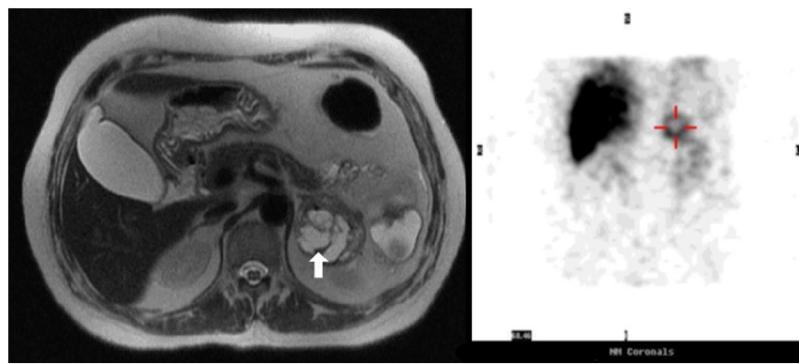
On the left: MRI, on T2, shows a 5.2 cm partially cystic mass (arrow) with a hyperintense solid component on T2. On the right: 123I-metaiodobenzylguanidine (MIBG) scan reveals high uptake of the lesion, that is at the topographical location of the left adrenal gland.
